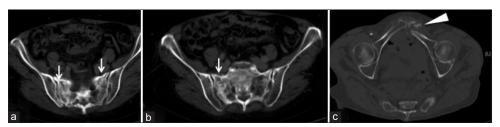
Axial computed tomography showing insufficiency fractures of both sacral ala (arrow) and left pubis (arrow head).
